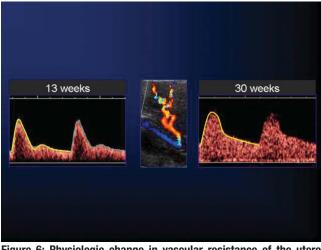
Physiologic change in vascular resistance of the uteroplacental circulation with advancing gestational age as observed on spectral Doppler of the uterine artery.
